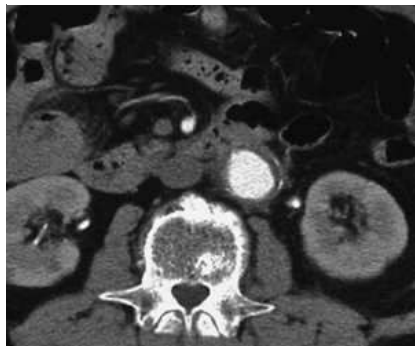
Computed tomogram, showing a protruding aorta compressing the third portion of the duodenum.
